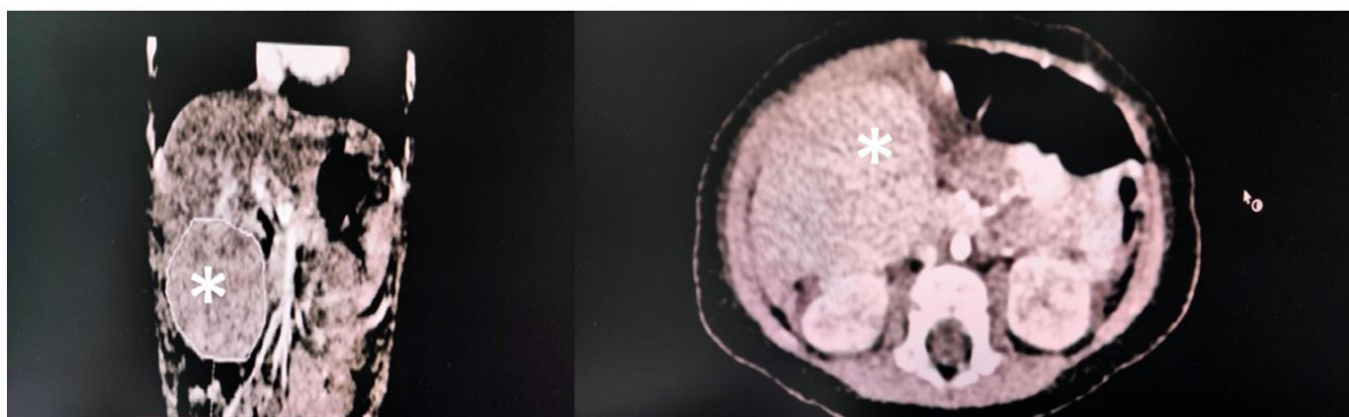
Computed tomography images of the mass, asterisks indicate the mass in coronal and axial planes
